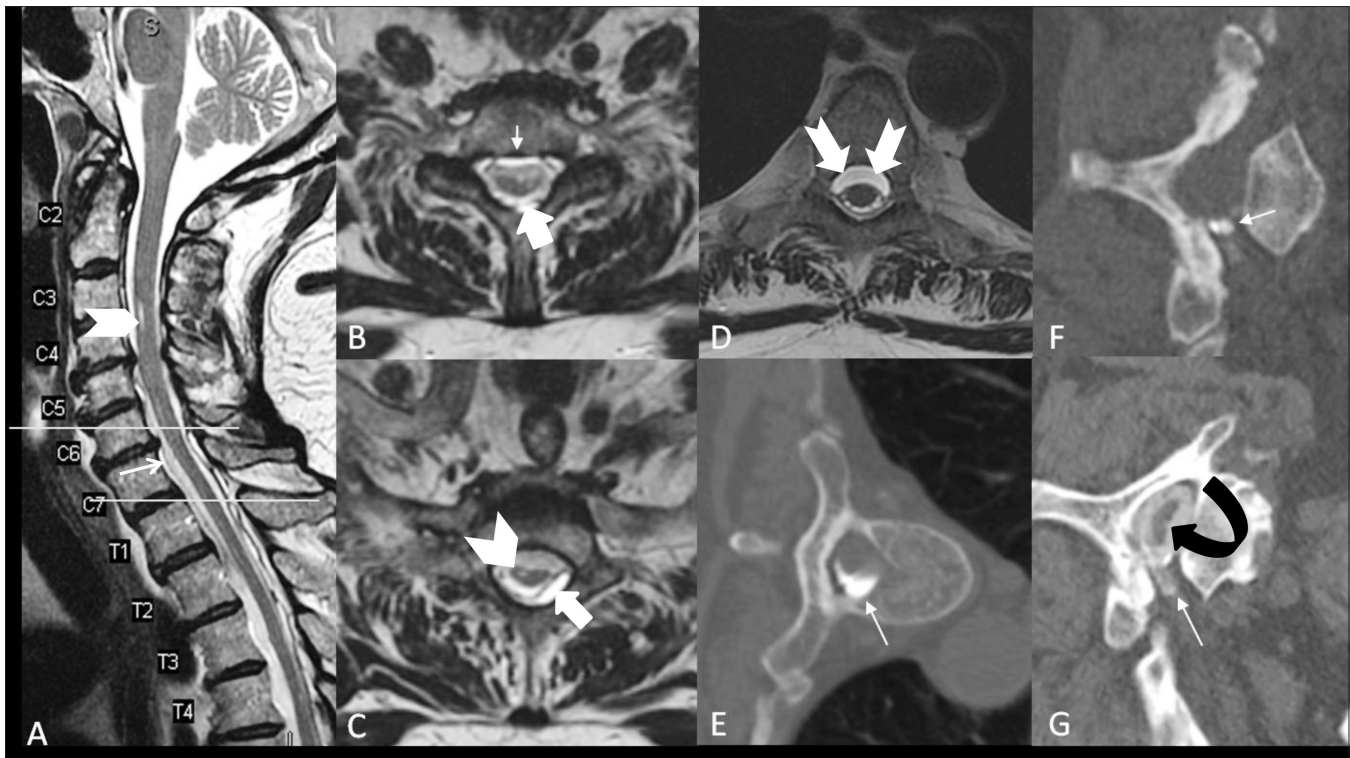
(A-G): Sagittal (A) and axial (B-D) T2W spine MRI showing extra-arachnoid fluid collection extending anteriorly from C₆ to T₁ level (thin white arrow), with mild indentation of the thecal sac, tracking to the left posterolateral epidural space (thick white arrow) from C₆ to T₂ level and becoming ventral in the upper thoracic spine (notched arrow). Cord T2 signal changes are also noted (arrow head) (A-C). Dynamic immediate CT myelogram (E, F) in left lateral decubitus position showed communication between the collection and thecal sac and asymmetric accumulation of contrast in the left C₆ perineural sheath (white arrow), suggestive of traumatic pseudomeningocele (F). On the delayed CT myelogram images (G) there was progressively increasing accumulation of contrast within the ventral extra arachnoid collection (curved arrow)
